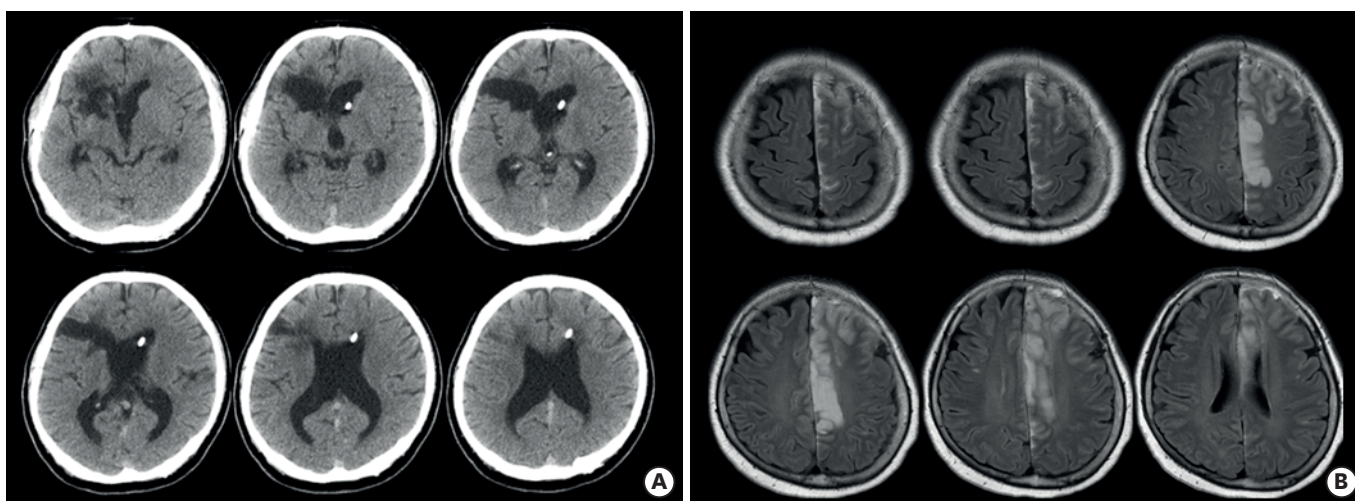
Brain images of 2 stroke patients. (A) Brain CT of case 1. (B) Brain MRI of case 2. CT, computed tomography; MRI, magnetic resonance imaging.
